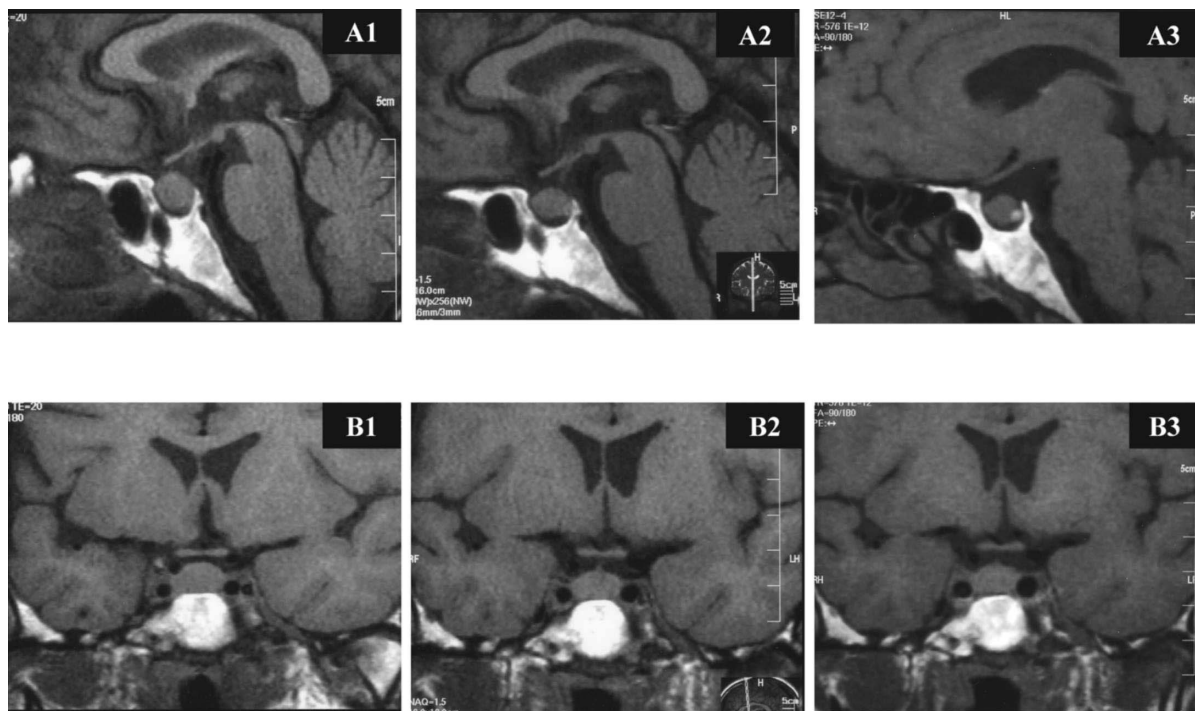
Characteristics of the pituitary gland on T1-weighted MRI
